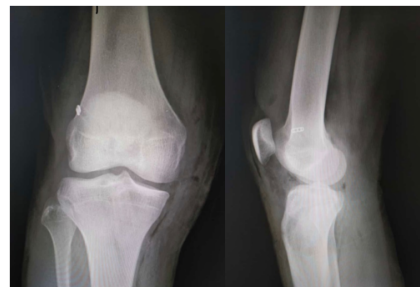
Post op X-ray shows ACL reconstruction done using Bioabsorbable screw.
